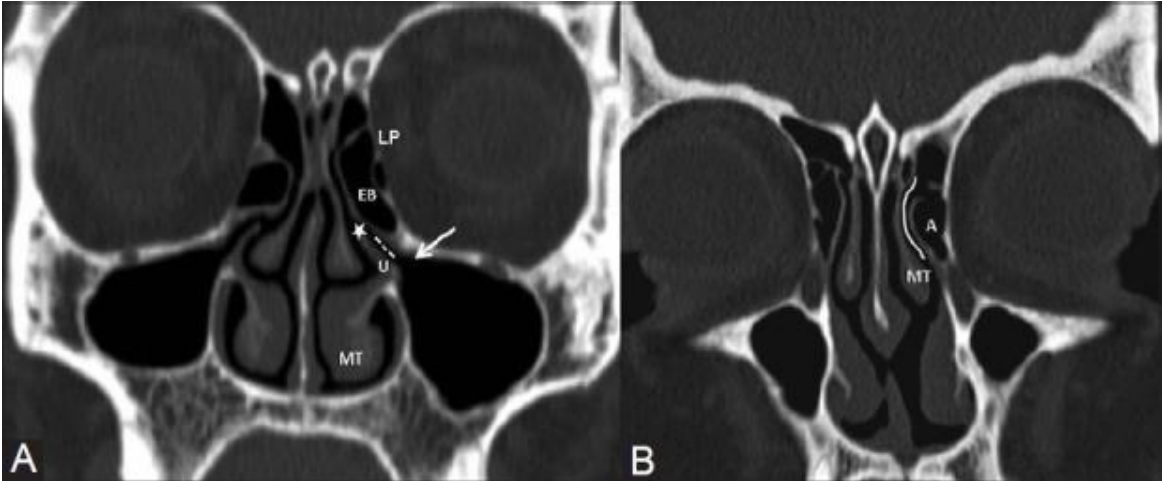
Coronal CT scan. (A) Shows the osteomeatal complex which consists of the following structures: infundibulum (dotted line), hiatus semilunaris (asterisk), maxillary ostium (arrow) and the ethmoidal bulla (EB). Middle turbinate (MT), Lamina papyracea (LP). (B) Shows agger nasi cell (A) which are inferior and lateral to the nasofrontal recess (solid white curved line). The middle turbinate (MT) forms the medial relationship of the recess. Taken from: Reddy UDMA, Dev B. Pictorial essay: Anatomical variations of paranasal sinuses on multidetector computed tomography-How does it help FESS surgeons? The Indian Journal of Radiology & Imaging Sciences 2012;22(4):317-24.
